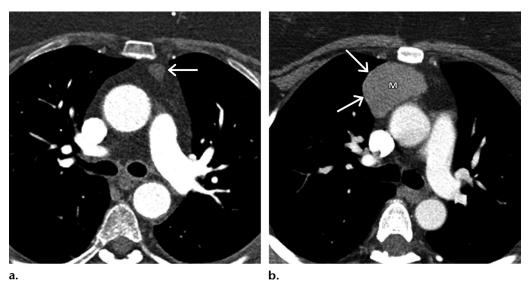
T1 neoplasms. (a) T1a disease in a 49-year-old woman. Coned-down axial contrast-enhanced multidetector CT image at the level of the left pulmonary artery shows a thymoma (arrow) confined to the fat of the prevascular mediastinal compartment without involving the mediastinal pleura. These findings were confirmed at surgery as T1a disease. (b) T1b disease in a 41-year-old woman with thymoma. Coned-down axial contrastenhanced multidetector CT image at the level of the left pulmonary artery shows the primary malignancy (*M*) in the right prevascular mediastinum, abutting and bulging into the mediastinal pleura (arrows), which was later proven to be involved. These findings are compatible with T1b disease.
